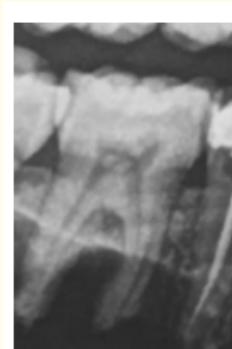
The precise volume of the pulpolith in the pulp chamber was assessed in the radiograph.
